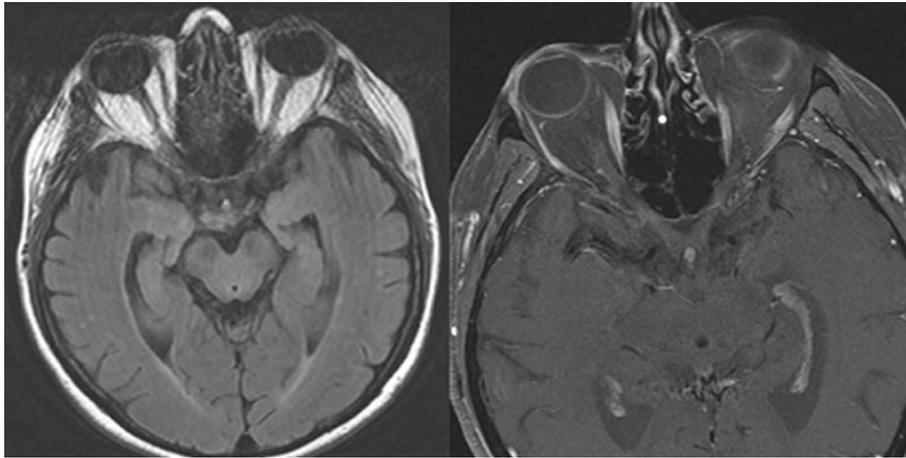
MRI of the brain and orbits - flare and T1 images demonstrate extensive non-enhancing white matter disease consistent with small vessel ischemic changes. However, there were no abnormalities of the orbit and no optic nerve enhancement.
